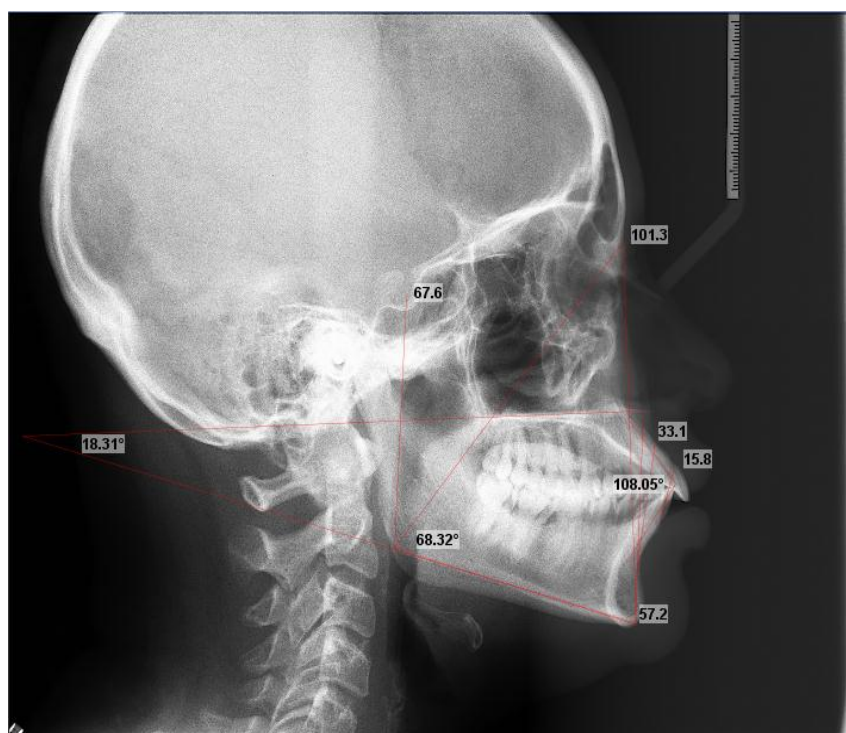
Lateral cephalometric Radiograph showing the measurements
